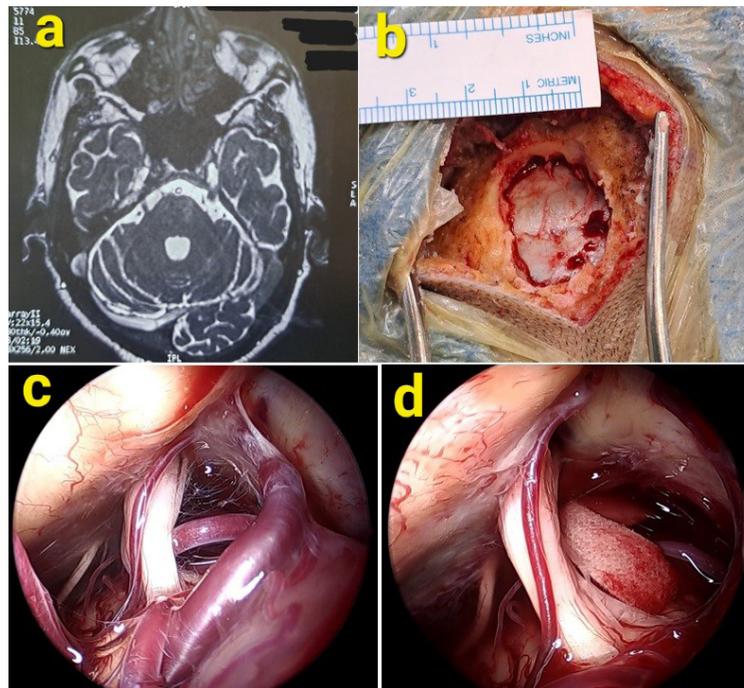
MRI and operative findings of microvascular decompression
